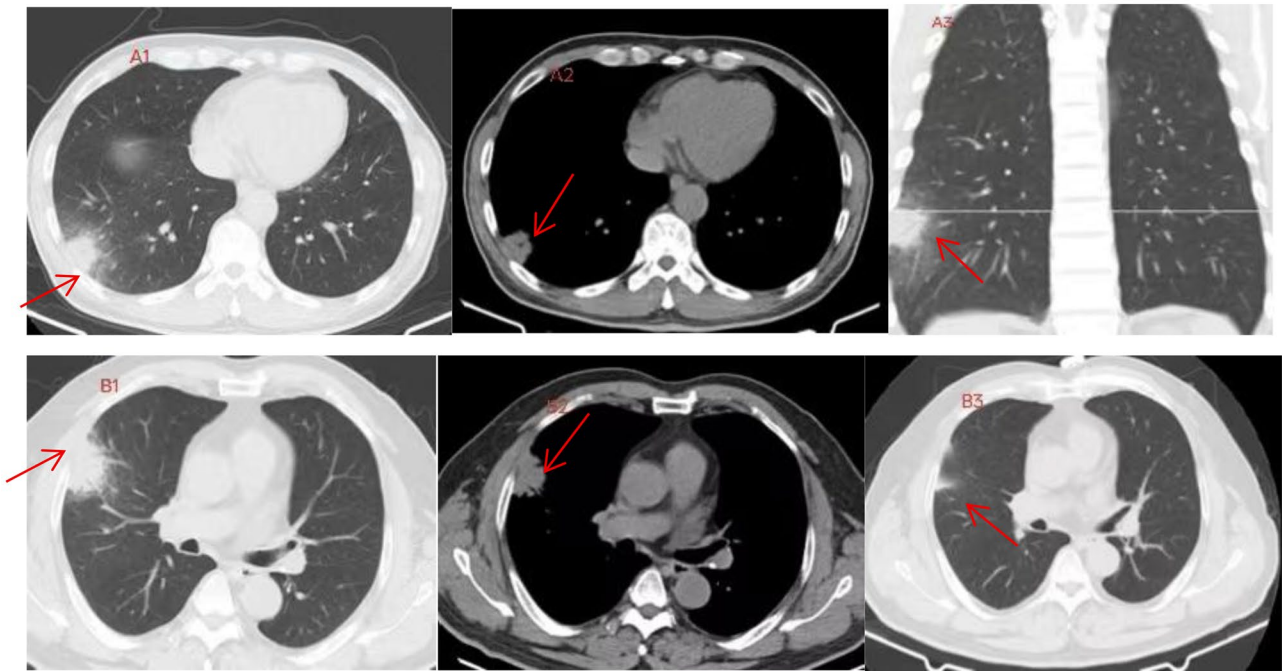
Chest CT findings in two patients with acute Q fever pneumonia. Figure A. A 62-year-old male patient with right upper lobe consolidation. (A1) Axial lung window image shows subpleural consolidation in the right upper lobe (arrow). (A2) Axial mediastinal window image reveals no mediastinal lymphadenopathy or pleural effusion, with the subpleural consolidation also visible (arrow). (A3) Coronal reformatted image (lung window) demonstrates the craniocaudal extent of the consolidation (arrow). Figure B A 53-year-old male patient with right lower lobe consolidation. (B1) Axial lung window image shows patchy consolidation in the right lower lobe (arrowhead). (B2) Axial mediastinal window image shows no associated mediastinal abnormality, with the subpleural consolidation also visible (arrowhead). (B3) Follow-up axial lung window CT obtained 2 weeks after treatment (doxycycline) demonstrates partial resolution of the consolidation (arrowhead)
